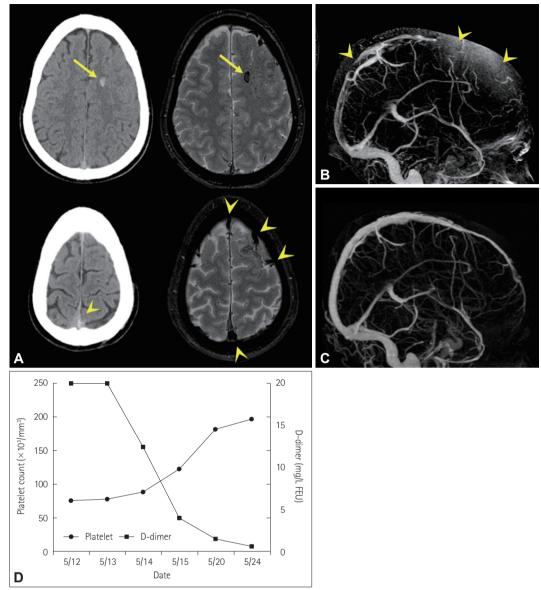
A: CT (left panel) and gradient recalled echo (right panel) images showing a focal intracranial hemorrhage in the left frontal lobe (arrows), and hyperattenuating and hypointense lesions due to venous thrombosis in the superior sagittal sinus and cortical veins (arrowheads). B and C: Massive cerebral venous thrombosis (arrowheads) in the superior sagittal sinus and cortical veins was evident on initial CT venography (B), which had resolved on repeat venography (C). D: Dual-axis graph showing a gradual increase in the platelet count (circles) and a reduction in the D-dimer level (square) over 2 weeks. FEU, fibrinogen equivalent unit.
